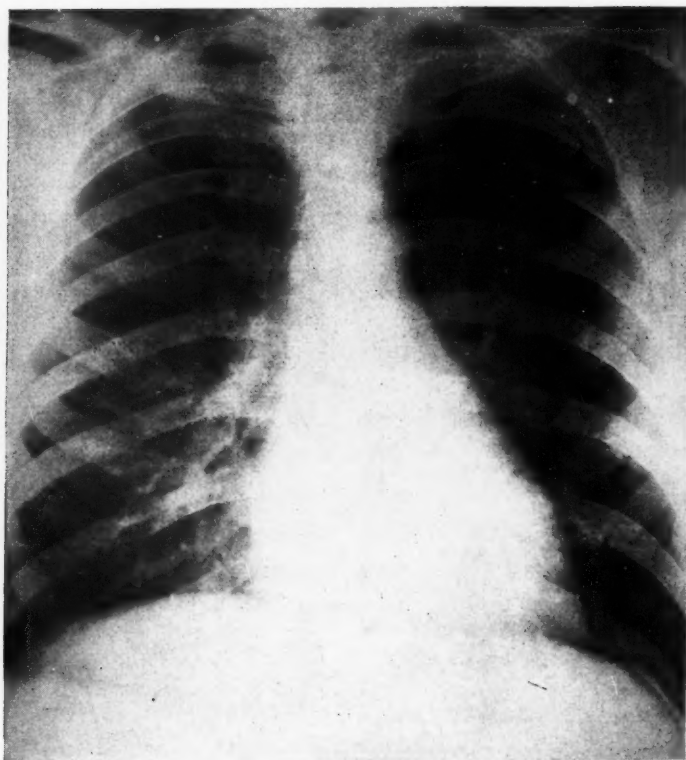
X-ray of chest in November, 1953, showing heart of normal size and configuration.
